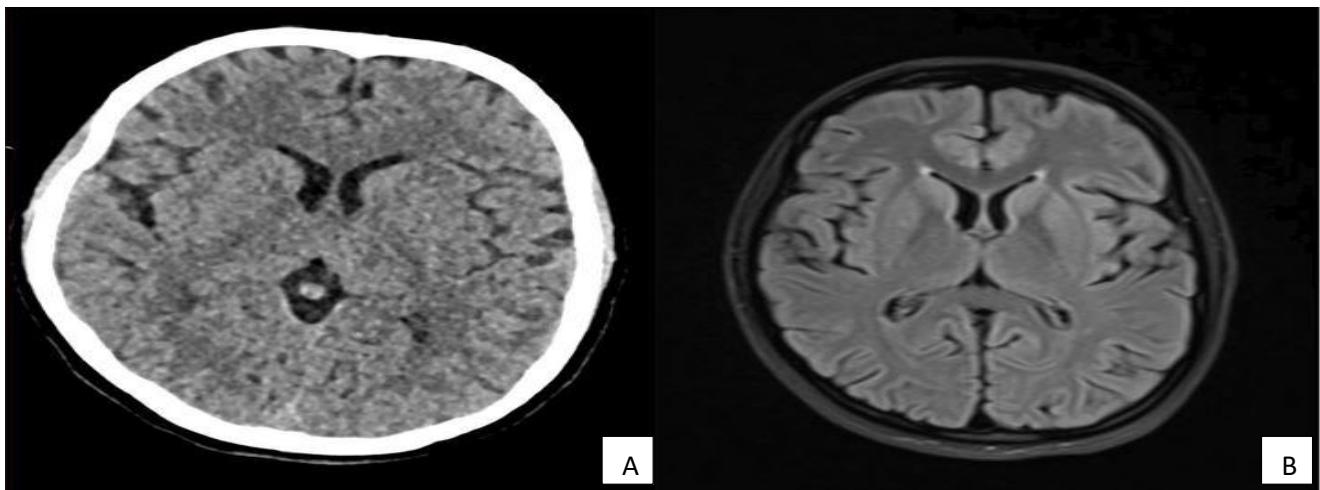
(A and B): Axial section of CT-brain and FLAIR MRI brain revealed no structural brain defect, or anomaly to which seizure activity could be attributed.
